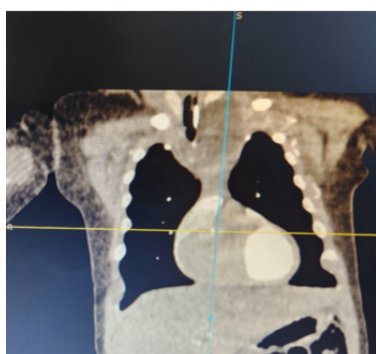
Coronal view of HRCT of thorax showed homogenous mass on the left of trachea causing compression of trachea and displacement of trachea to the right.
